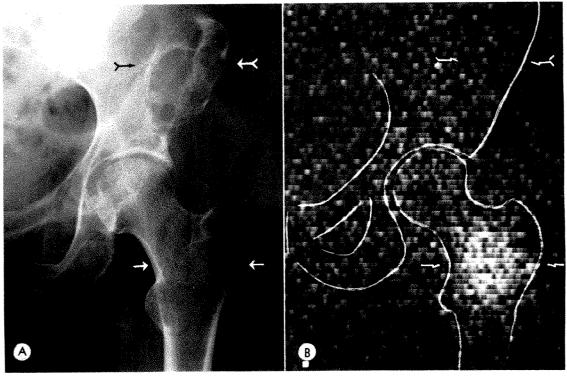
(A) Enchondroma of the right femur in a 61 year old woman. (B) Arteriogram reveals normal blood supply to the femur. (C) Scintigram shows increased radioactivity in the distal tumor part \uparrow , where active proliferation is present. There are negative scintigraphic findings in the inactive, proximal tumor part \uparrow . (Reproduced with permission from: Bessler W., Radioisotope in der Lokalisationsdiagnostik. F. K. Schattauer-Verlag, Stuttgart, 1967, 431.)
